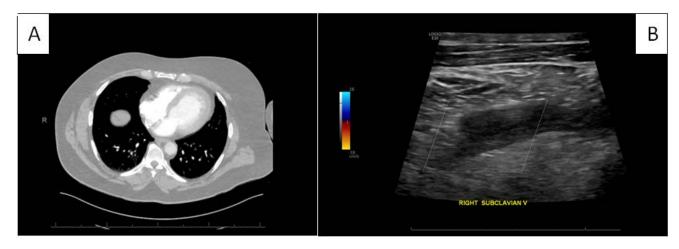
CTA of the chest showing small right lower lobe segmental pulmonary artery embolus (A). Venous doppler ultrasound of the right upper extremity showing an occlusive thrombosis of the right subclavian (B)
